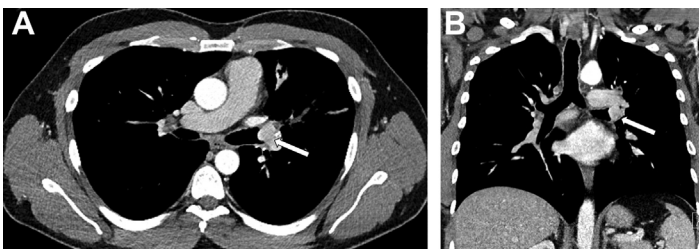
Axial (A) and coronal (B) contrast-enhanced CT images of the chest demonstrate an avidly enhancing endobronchial lesion in the left mainstem bronchus (arrow), consistent with a lung carcinoid.
